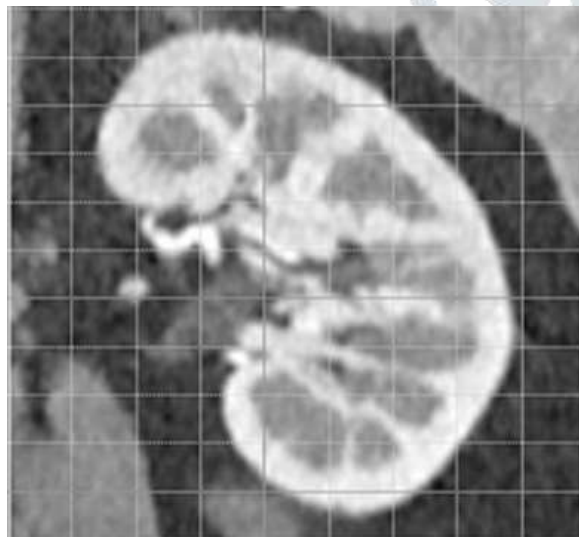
MRI image of the Kidney with the presence of Chronic Kidney Diseases
